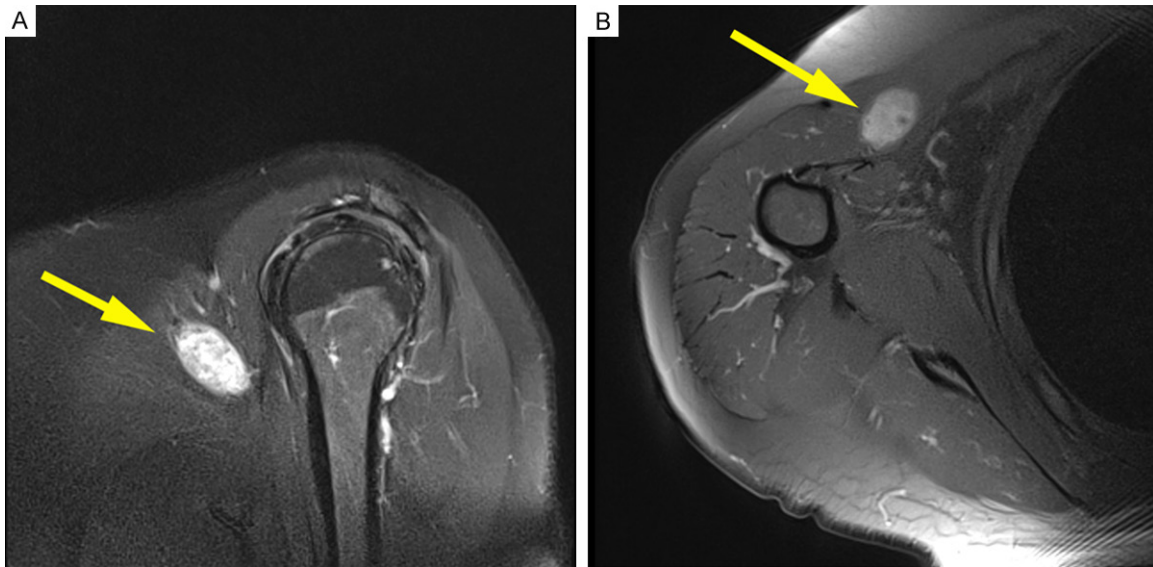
Magnetic resonance imaging revealed a well-defined hyperintense mass (arrow) on T2-weighted image in coronal (A) and transverse (B) planes.
